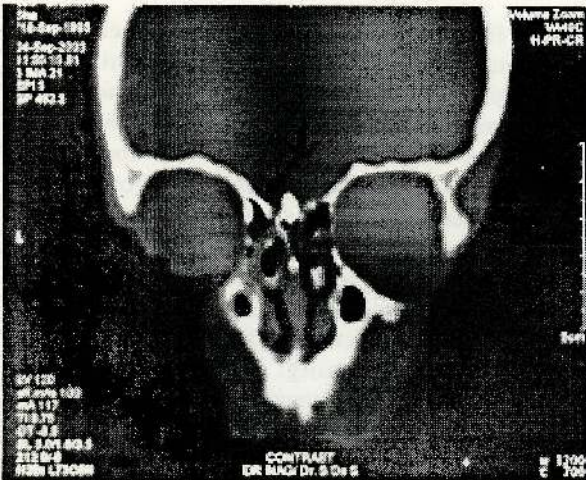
CT scan showing defect in cribriform plate.
